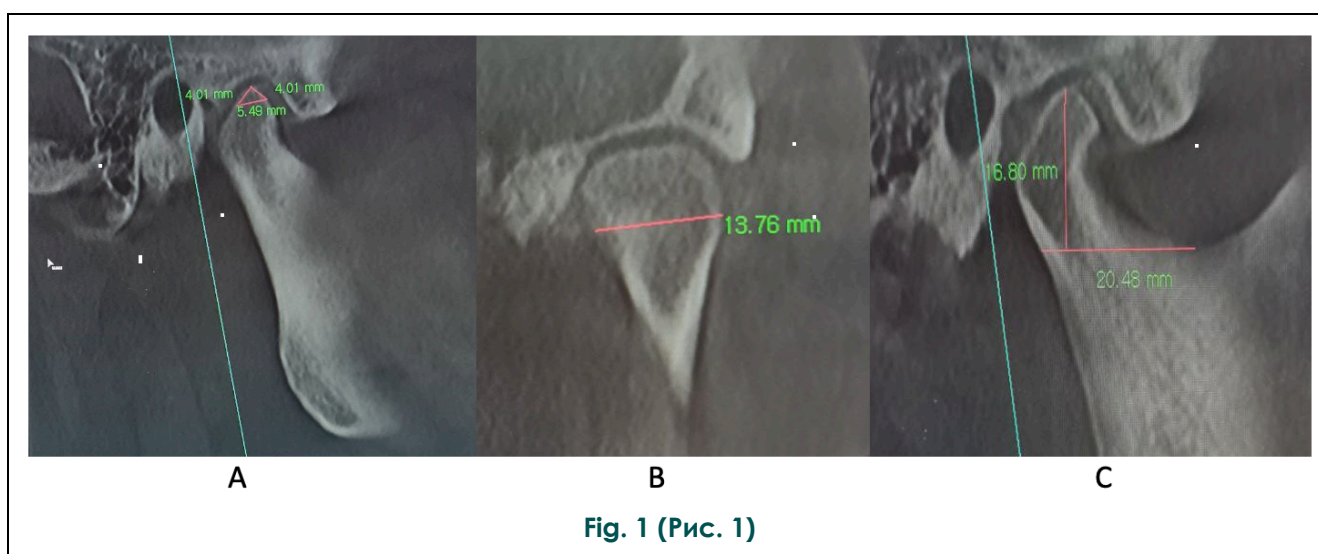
CBCT, mandibular condyle.
